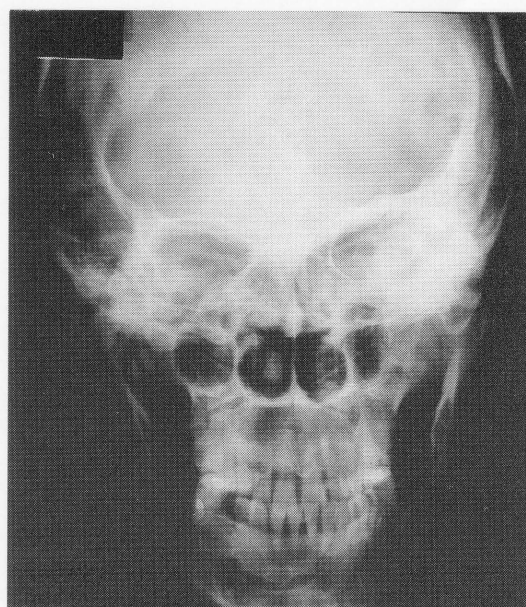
Case 1. Radiography of the skull showed sclerosis and hyperplasia of the left facial bone.
